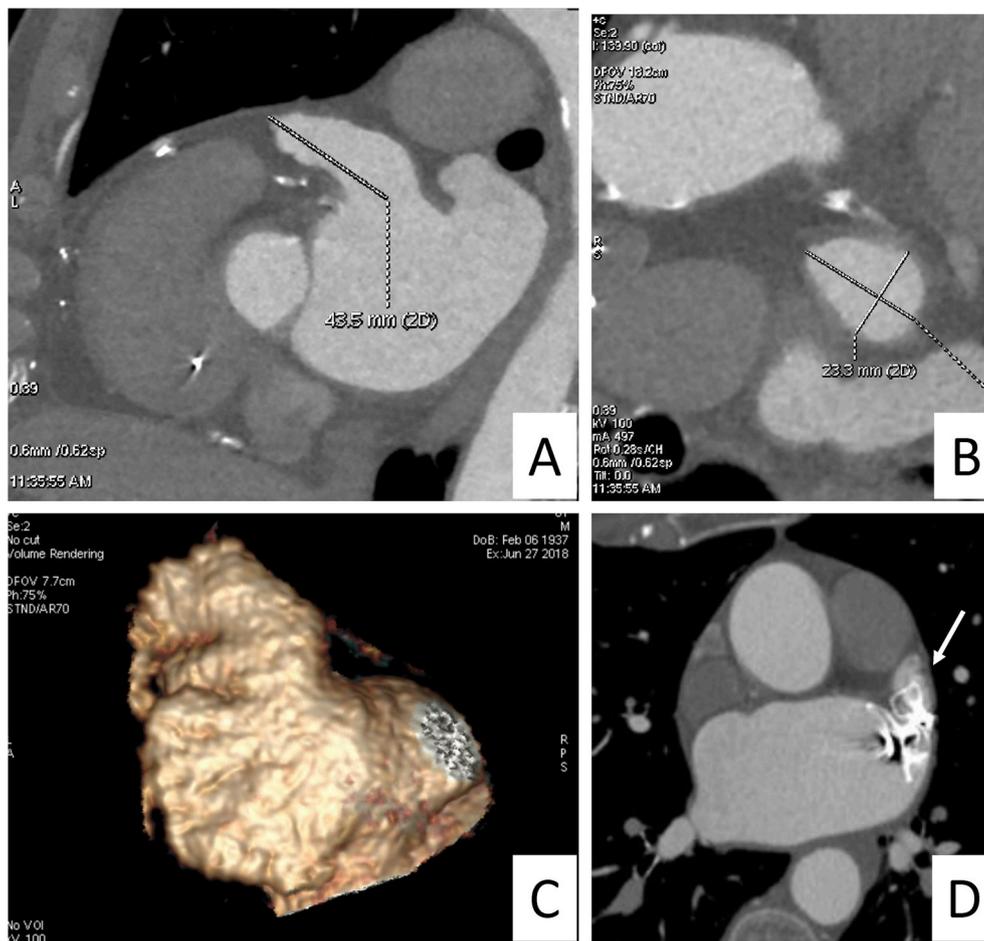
A and B. CCT measurements of LAA depth (A) and ostium diameters (B) C. CCT 3D volume rendering of LAA. D. Delayed CCT post contrast images showing residual leak in a patient who underwent LAA closure (white arrow). CCT: cardiac computed tomography; LAA: left atrial appendage.
